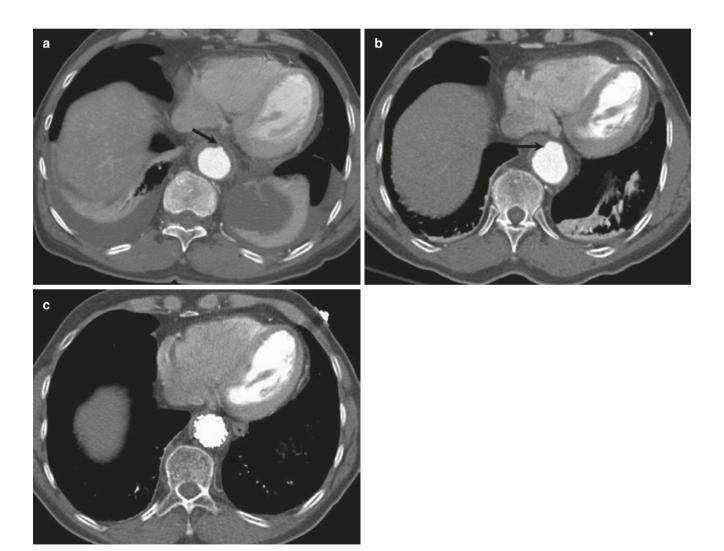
Complication of intramural hematoma. (a) Axial image of initial CT aortogram shows a near circumferential intramural hematoma with focal penetrating "ulcer-like" projection anteriorly (arrow).
